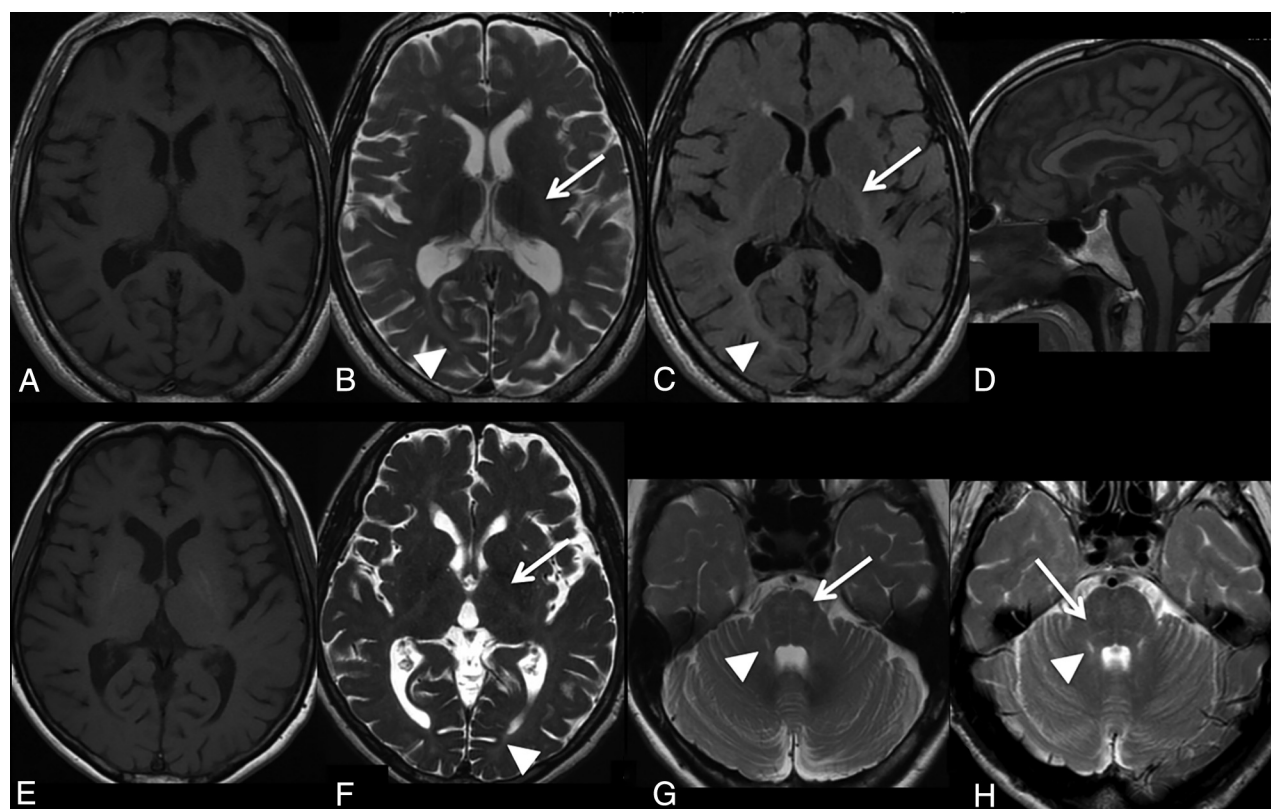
Axial scans of patients 8 (A–C) and 7 (E and F) show isointense-to-mild hyperintense T1-weighted signal (A and E) associated with mild-to-moderate hyperintense T2- (B and F) and FLAIR-weighted (C) signal of the white matter, especially the internal capsules (arrows) and optic radiations (arrowheads). Sagittal T1-weighted image of patient 8 (D) shows atrophy of the corpus callosum and the vermis. T2-weighted images of patients 2 (G) and 4 (H) show mild hyperintense signal of the corticospinal tract in the ventral pons (arrows) and cerebellar peduncles (arrowheads).
